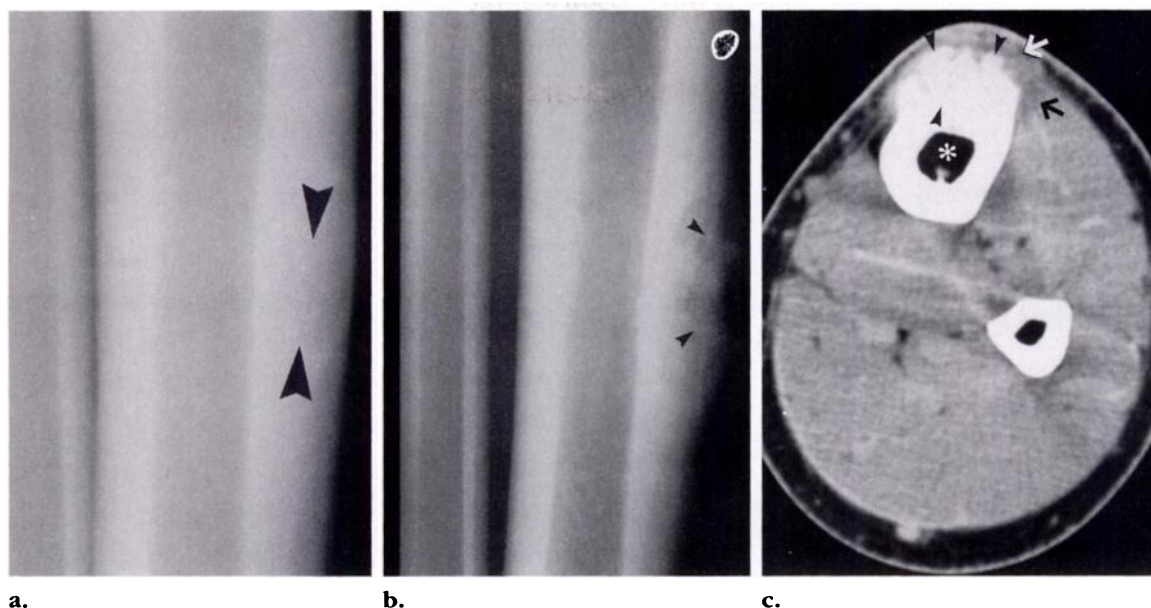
Intracortical osteosarcoma of the anterior tibia in a 20-year-old man with shin pain. (a) Lateral radiograph obtained at initial presentation shows a vague, entirely intracortical area of lucency (arrowheads) in the anterior cortex of the tibial diaphysis. (b, c) Lateral radiograph (b) and axial CT scan (c) obtained 6 months later reveal lesion enlargement with osteoid mineralization (arrowheads) and extension into anterior soft tissues (arrows). Medullary canal is normal (*).
